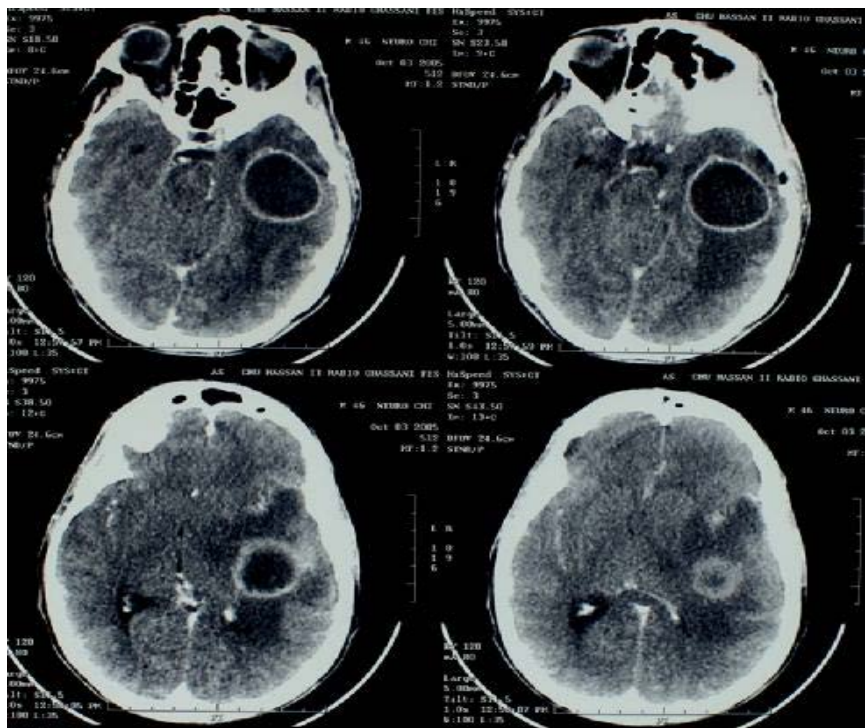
CT scan with contrast (A and B) axial slide and (C and D) coronal slide shows the midline frontal empyema.
